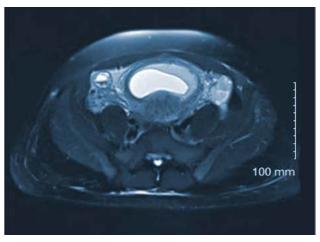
Axial view of T2 weighted MRI without contrast showing an IUP and right sided 17 mm complex paraovarian mass suspicious for ectopic gestation
